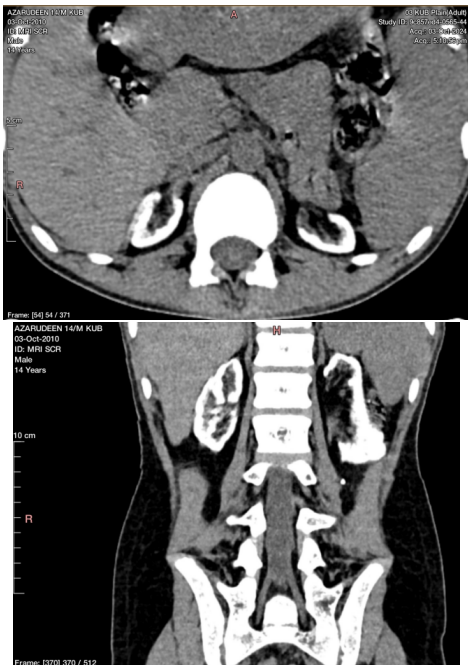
CT scan axial (left) and coronal (right) showing cortical nephrocalcinosis in a 14 year old patient with Primary Hyperoxaluria Type - I
